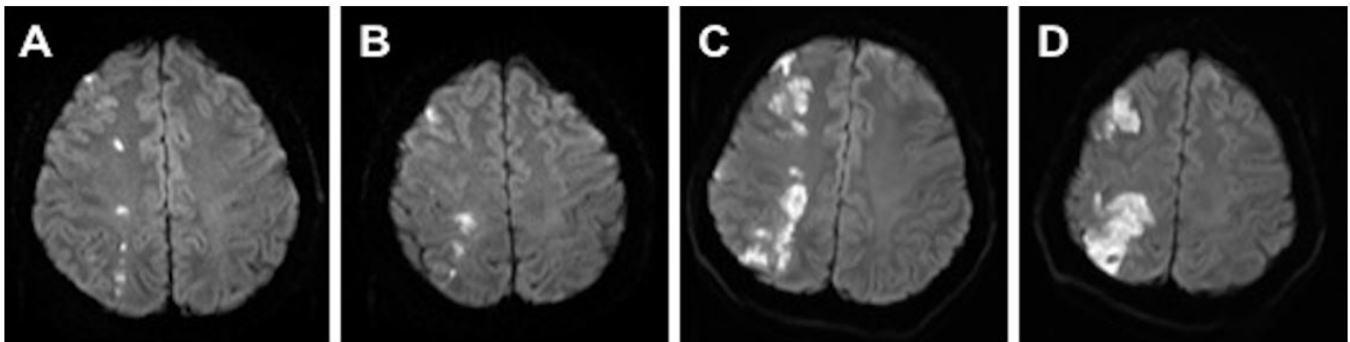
Progression of watershed infarct in the DWI sequences of MRI from admission (slices A & B) to the 6th day (slices C & D)
